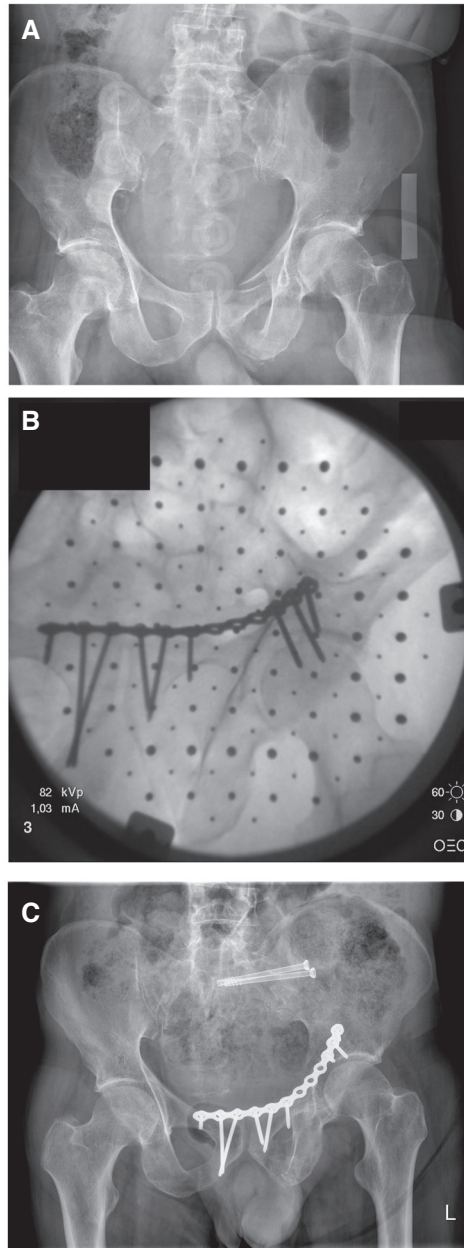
Fig 3A: type C injury with T-POD in place. Fig 3B: fluoroscopy during plate fixation anterior ring. Fig 3C: post-operative x-ray after definitive care (placement SI screws left)
